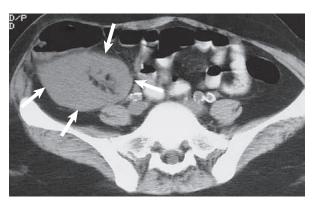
Normal renal transplant (arrows) on CT.
